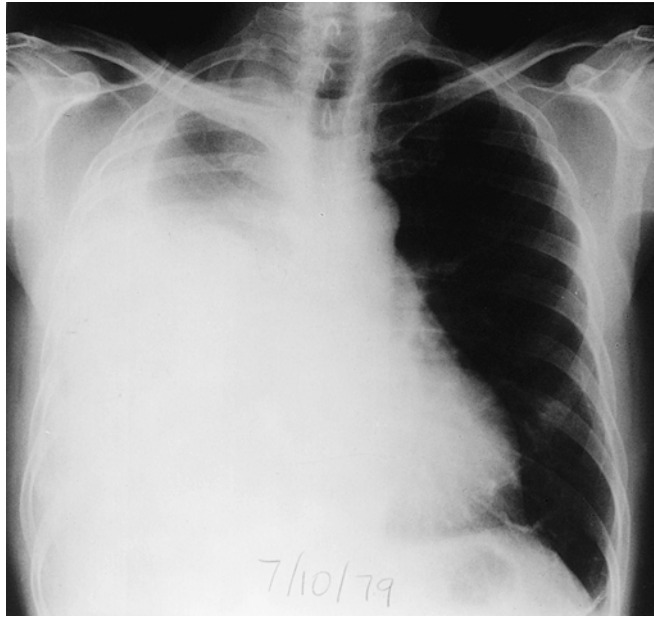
Chest x-ray of the same patient as in Figure 24.1 at presentation in July 1979. Massive right pleural effusion. Pleural biopsy showed malignant epithelial mesothelioma.
